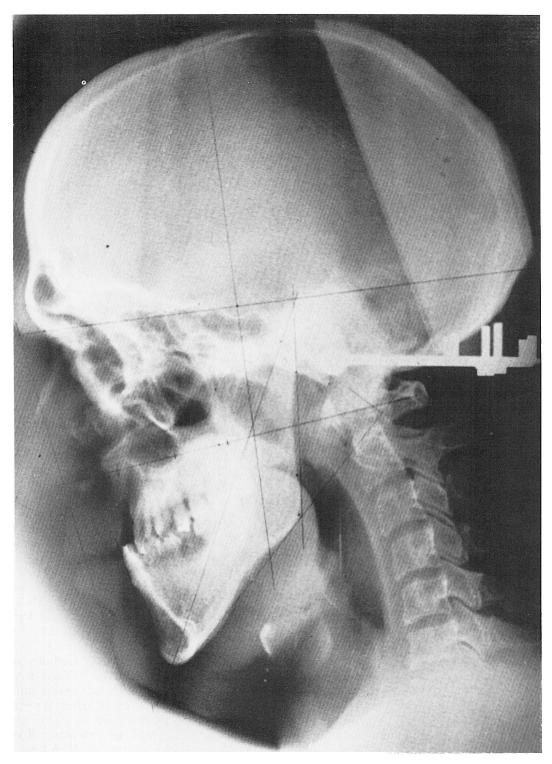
X-ray film in a patient with incomplete cleft palate showing the masking of the maxillar retrusion by the soft tissues of the upper lip.
